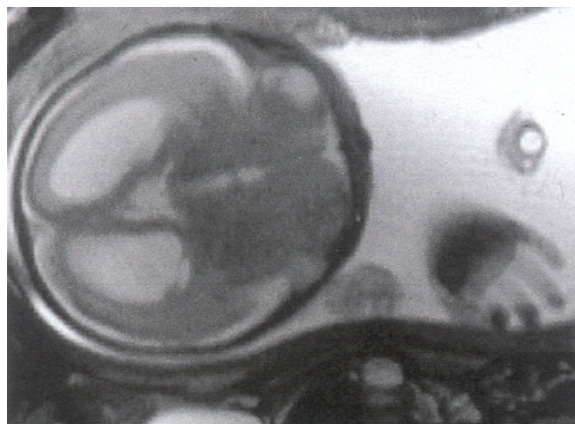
Head T2 axial plane MRI scan at 34 weeks of gestation, demonstrating colpocephaly in the agenesis of the corpus callosum.
